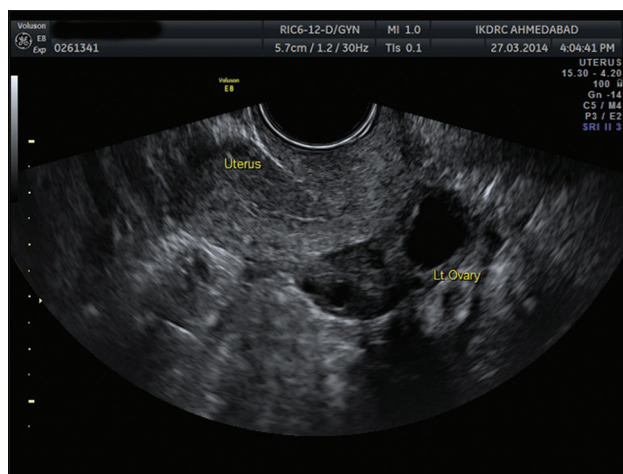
Transvaginal sonography showing hypoplastic uterus and normal left ovary
